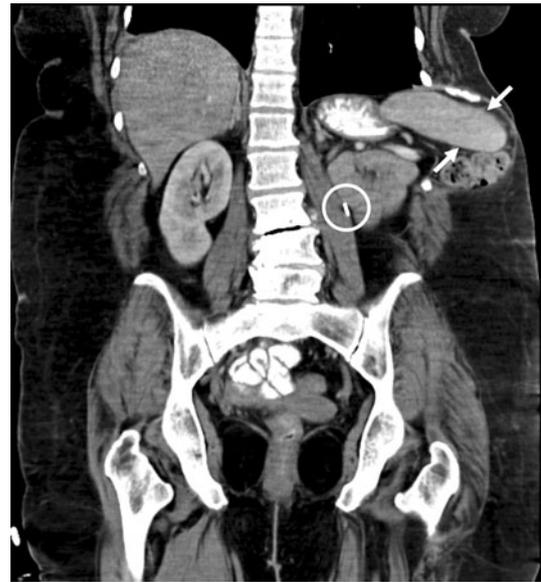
Coronal contrast enhanced computed tomographic image in soft tissue windows demonstrating the herniation of spleen (*arrows*) and small bowel through the tenth and eleventh intercostal space as well as an absent left kidney with surgical clip (*circle*), consistent with prior laparoscopic nephrectomy
